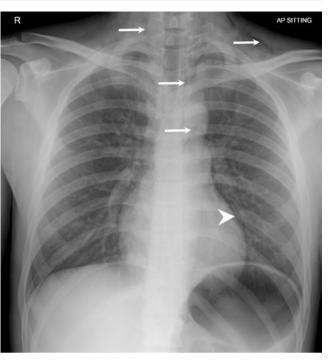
A 29-year-old asthmatic presenting to emergency department with acute onset chest pain. Frontal chest radiograph shows paracardiac lucency (arrowhead) and streaky lucencies over the mediastinum extending in the neck and supraclavicular fossa (white arrows)
